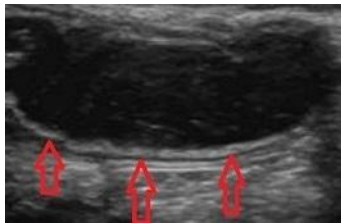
Ultrasound appearance of a mucocoele marked by the red arrow.
